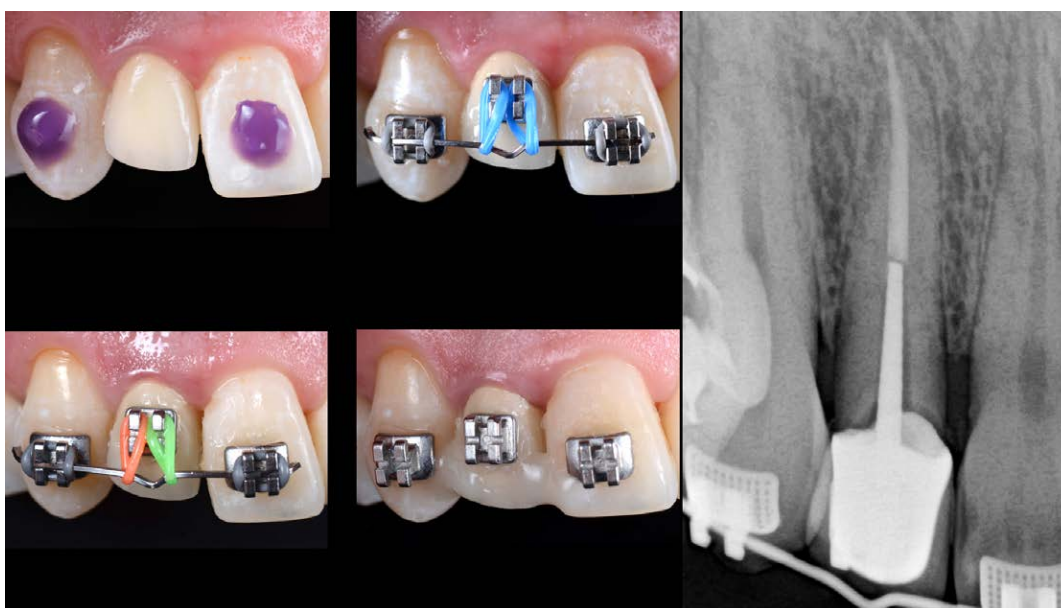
Phases of the orthodontic extrusion of the maxillary, right lateral incisor. Note the elastic thread was exerting force against the rectangular wire and the coronal migration of the gingival tissue. After three weeks, the extrusion was deemed sufficient and then splinted to the adjacent teeth. Post extrusion radiograph.
